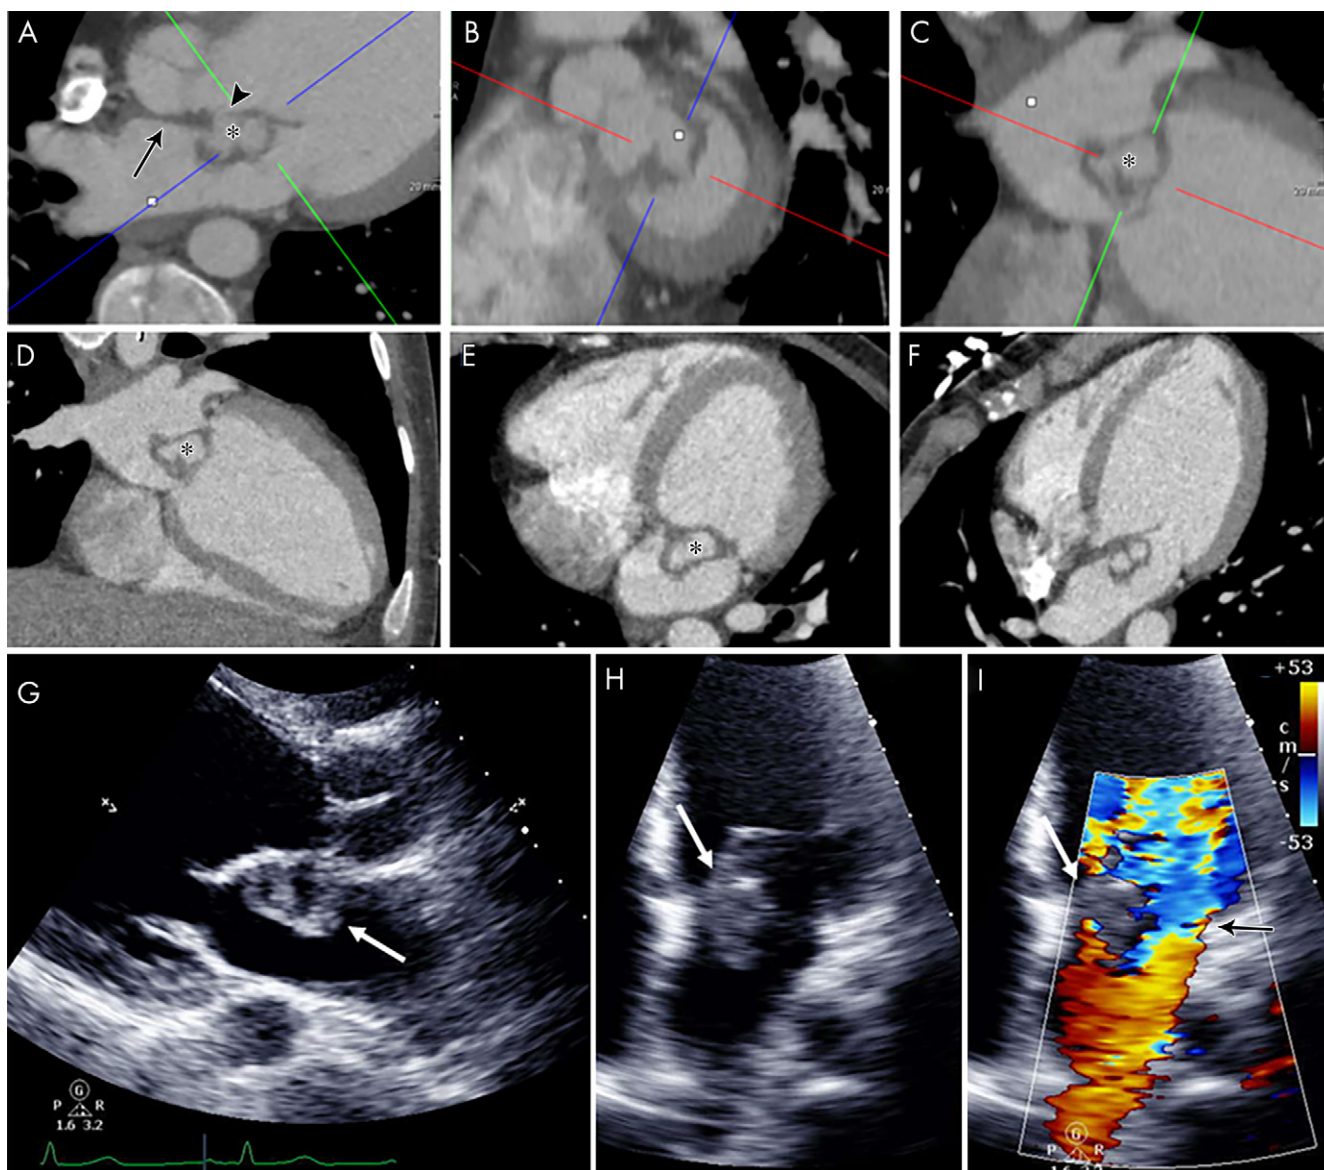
A–F, Contrast-enhanced CT images in a 21-year-old man show mitral valve leaflet thickening extending into the intervalvular fibrosa (arrow, A), anterior mitral valve leaflet elongation, and a contrast material–filled cavity (*) along the atrial side of the anterior leaflet outlined by bilobed low attenuation. The appearance is compatible with valve vegetation with abscess and/or pseudoaneurysm, which appears to communicate with the left ventricular outflow tract (arrowhead, A), giving a windsock appearance. The left ventricle appears dilated. G–I, Echocardiographic images in the same patient show heterogeneous echogenicity attached to the atrial side of the thickened anterior mitral leaflet with central echo poor areas (white arrows) and severe mitral regurgitation (black arrow on color Doppler image, I).
